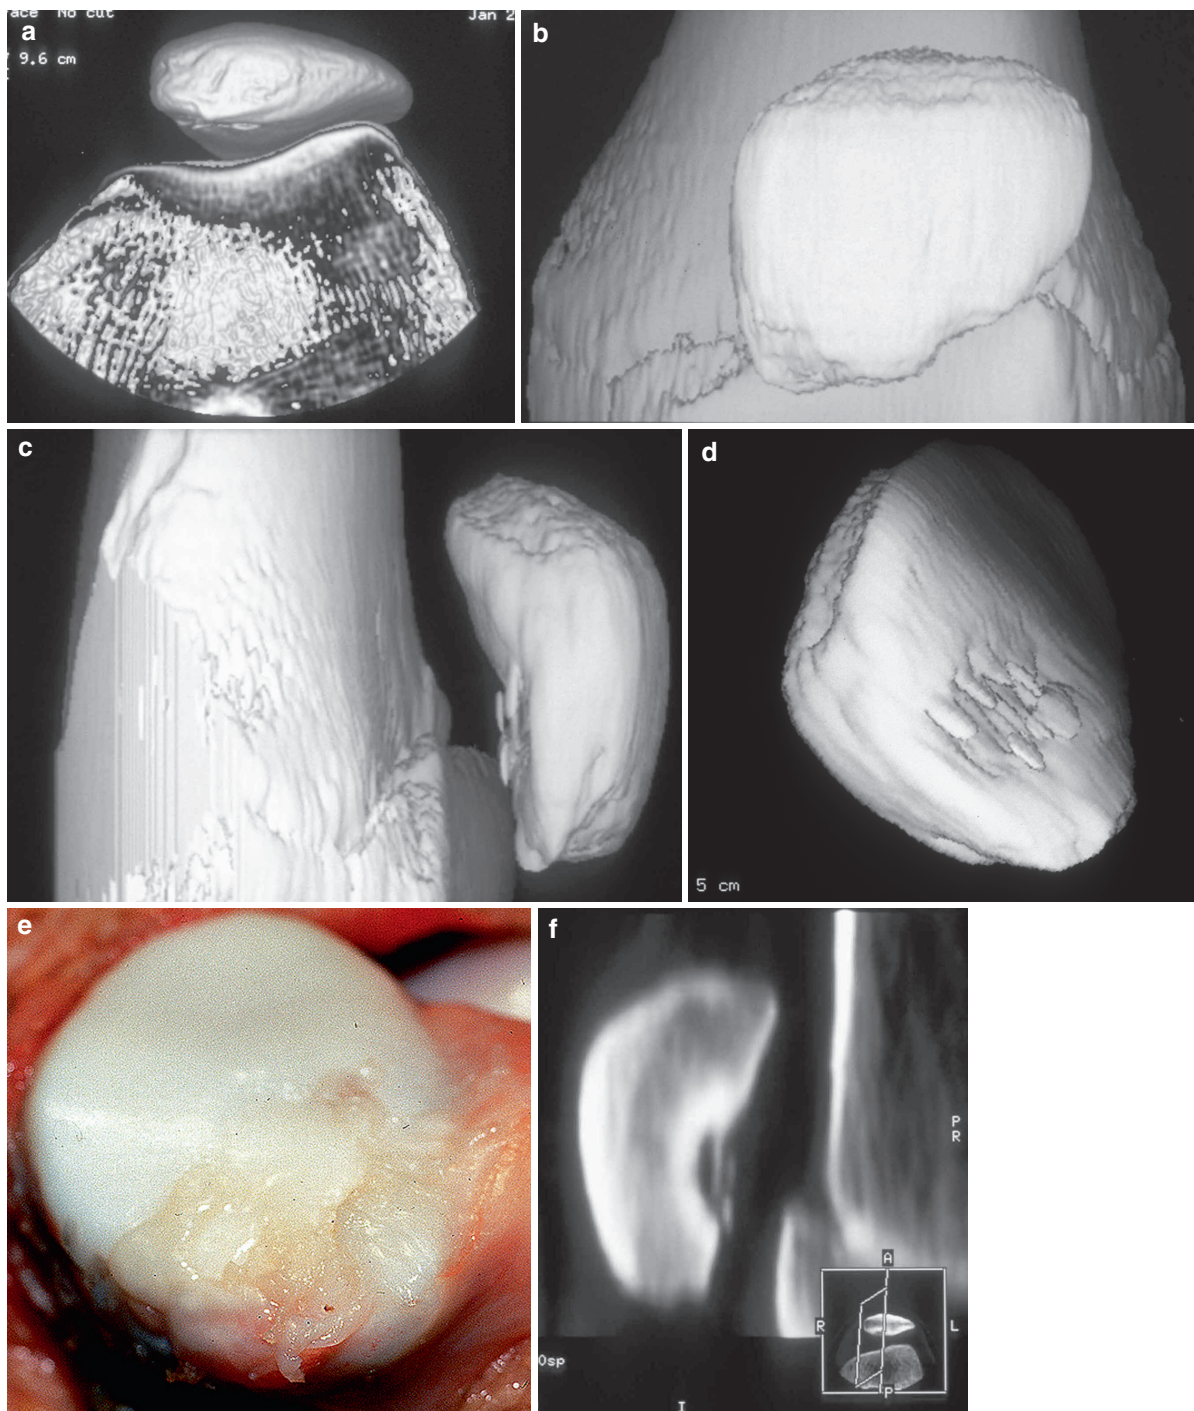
3D-CT reconstruction of the patellofemoral joint. Axial plane showing degenerative changes of the articular cartilage of the medial patellar facet (a), frontal plane (b), and sagittal plane (c). 3D-CT shows great fidelity of the surface anatomy
